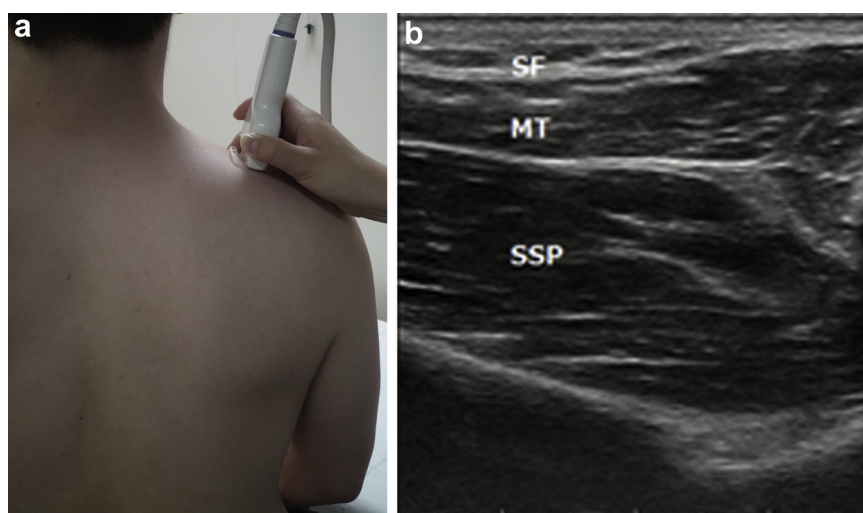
(a) Probe position for imaging supraspinatus muscle echogenicity. (b) Sonogram of a cross section of the supraspinatus muscle. MT = middle trapezius; SF = subcutaneous fat; SSP = supraspinatus.
